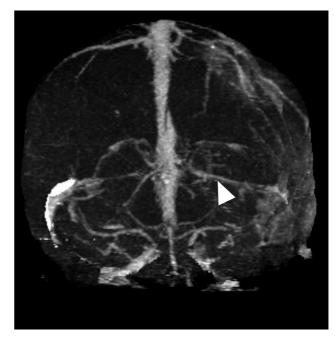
Computed tomographic venography 16 weeks postoperatively showing the presence blood flow within the left transverse sinus, indicative of recanalization of the sinus (arrowhead).
